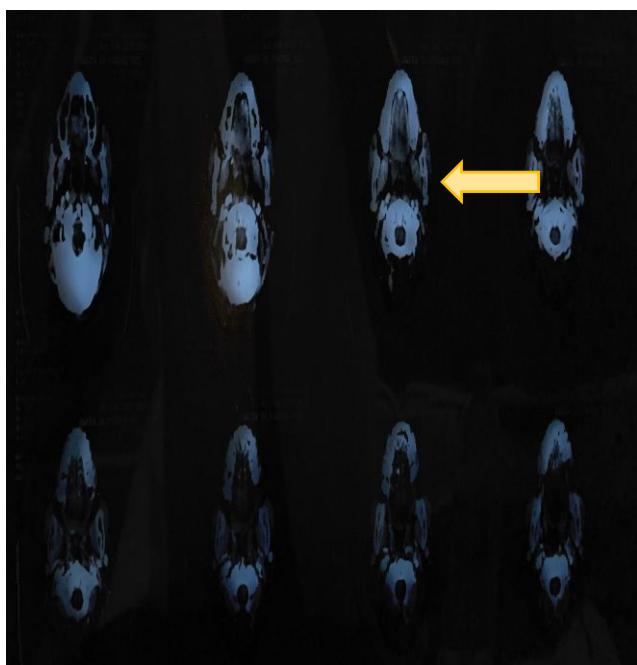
Contrast enhanced computed tomography of base of skull to diaphragm, showing infiltrative mass lesion of tongue, involving superficial cutaneous planes (arrows).
